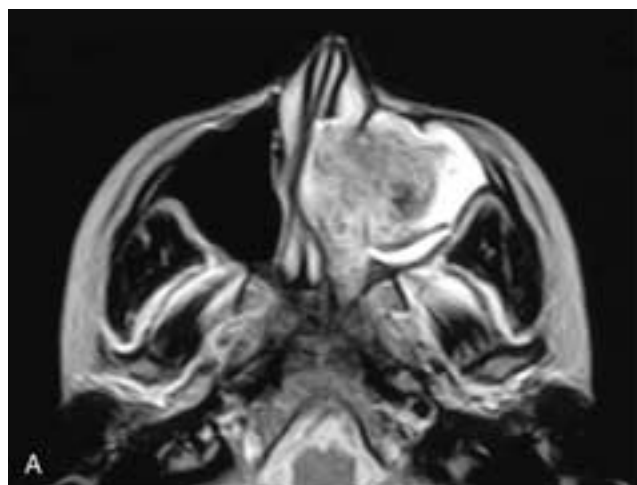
Axial T2-weighted (A) and T1-weighted, contrast-enhanced (B) MR images show an enhancing mass with an intermediate T2-weighted signal intensity in the left nasal fossa and maxillary sinus. Obstructed secretions are seen in the left antrum. Coronal CT scan (C) shows the mass to have diffuse calcifications. This patient had an olfactory neuroblastoma.
